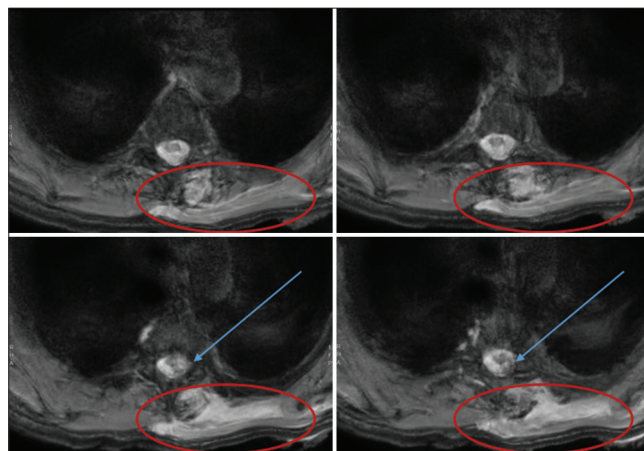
Spinal magnetic resonance imaging of patient 1. Axial slices, short-tau inversion recovery sequences. Red circles indicate a fracture of the articular facet, a laceration of the yellow ligament, and a contusion of the paravertebral tissues on the left. Blue arrows indicate the spinal cord lesion.
